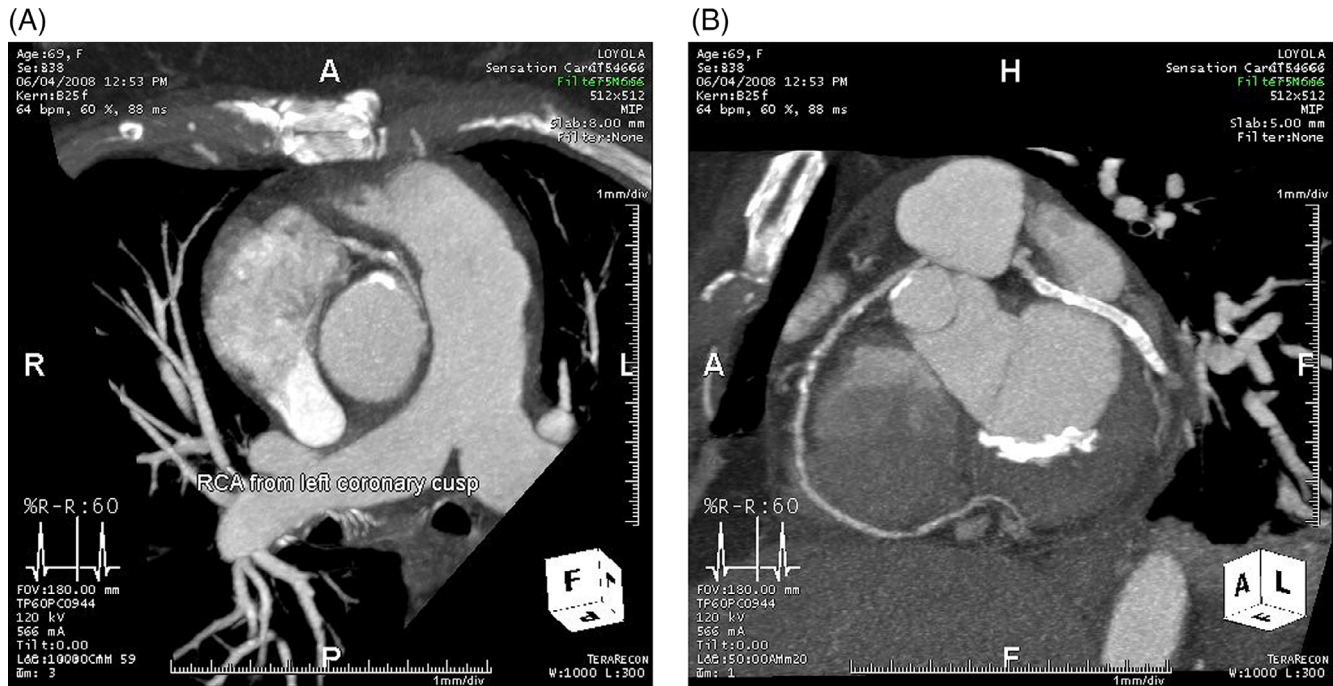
(a) Cardiac CTA image of the patient in Figure 1 showing an anomalous RCA arising from left coronary cusp. The proximal RCA courses between the ascending aorta and the main pulmonary artery. (b) The same cardiac CT showing mid and distal RCA. CT, computed tomography; RCA, right coronary artery [Color figure can be viewed at wileyonlinelibrary.com]
